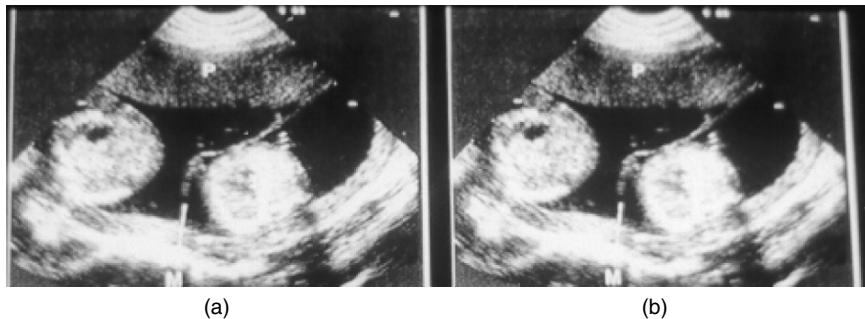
Result of interleaving ADM error signal in the Ultrasound image:
